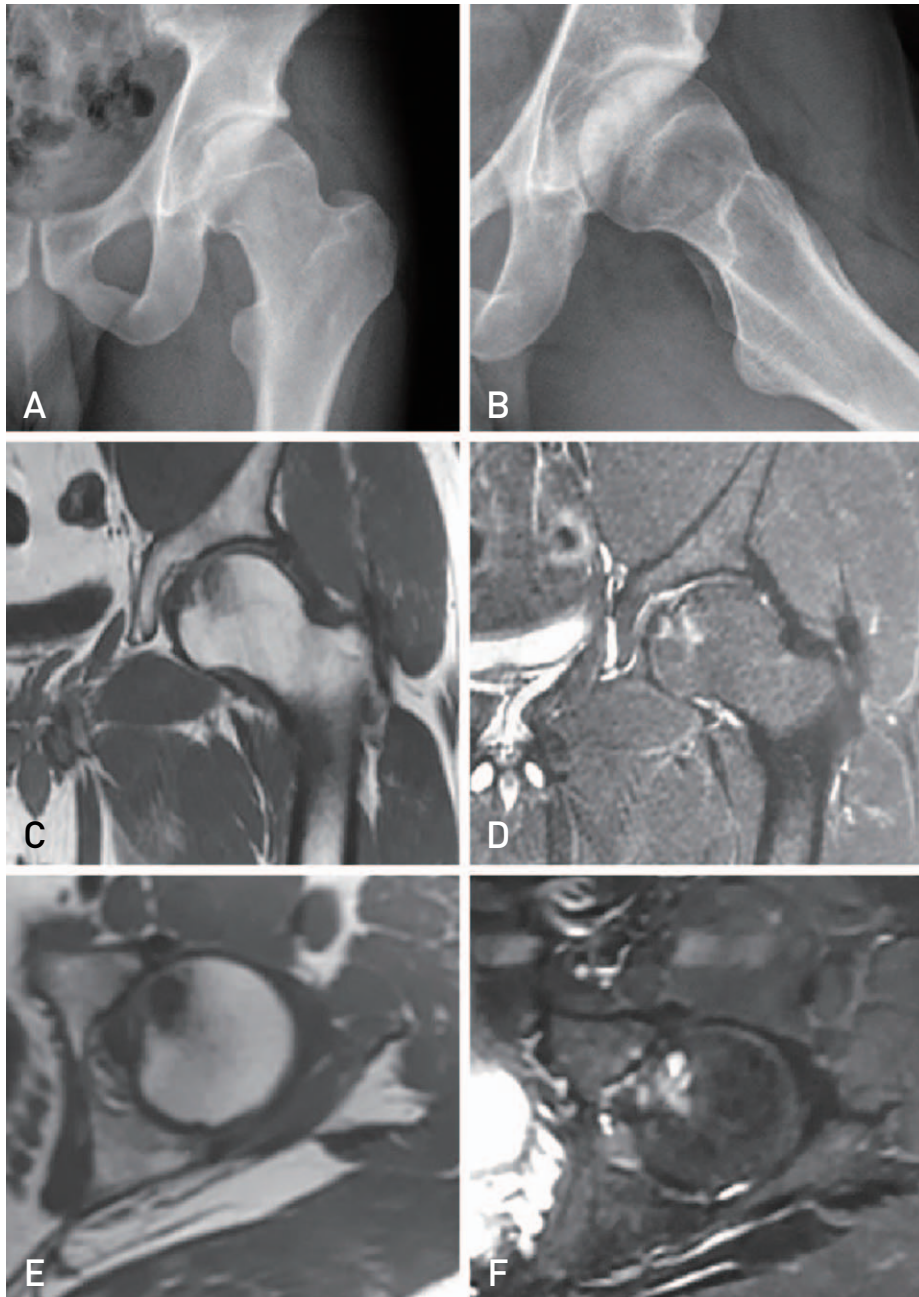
Preoperative imaging studies of a 21-year-old male with a symptomatic osteochondral lesions (OCL) of the left femoral head. (A) Anteroposterior and (B) lateral radiograph views show a well-preserved joint space and cam deformity. (C) Coronal T1-weighted and (D) fat-saturated T2-weighted magnetic resonance imaging (MRI) images showing the OCL. (E) Axial T1-weighted and (F) fat-saturated T2-weighted MRI images showing the OCL.
